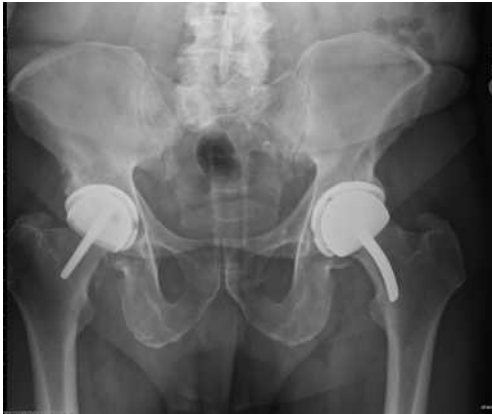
This AP radiograph of a 45-year-old man shows a right total hip replacement and a left hip resurfacing. The same size acetabular shell size was used on each side.
